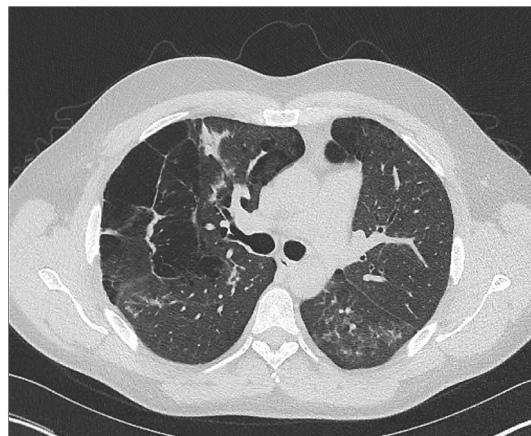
CT Chest 6 months following first course of rituximab with significant improvement in septal, reticular and ground glass changes.
